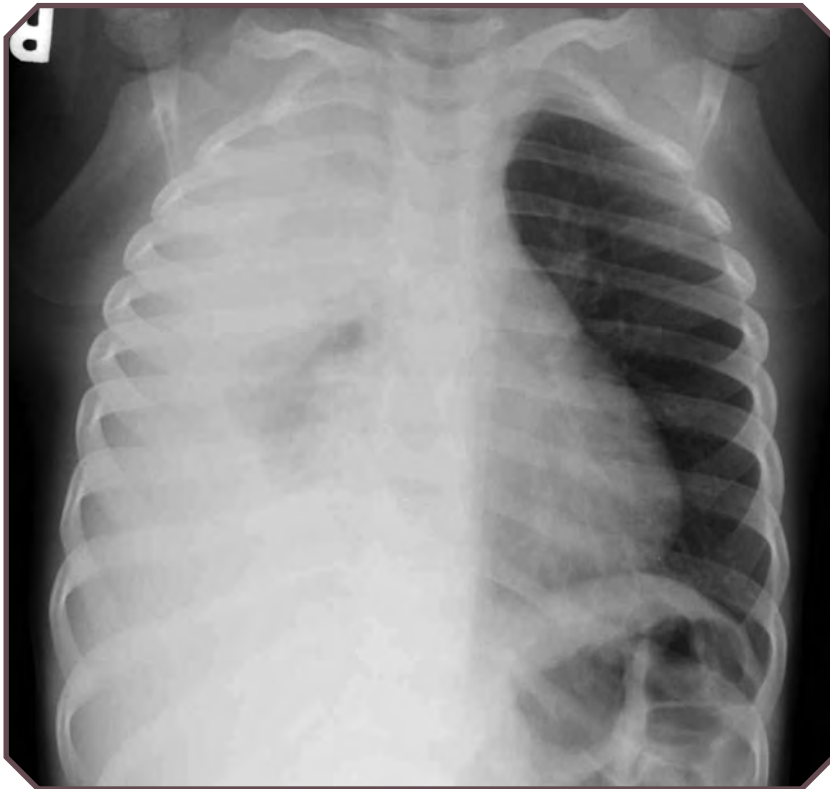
Right pleural effusion in a febrile 3-year-old girl with pneumonia. Frontal chest radiograph shows near-complete opacity of the right hemithorax with an effusion tracking up the right chest wall. Note right-to-left mediastinal shift due to large effusion.
